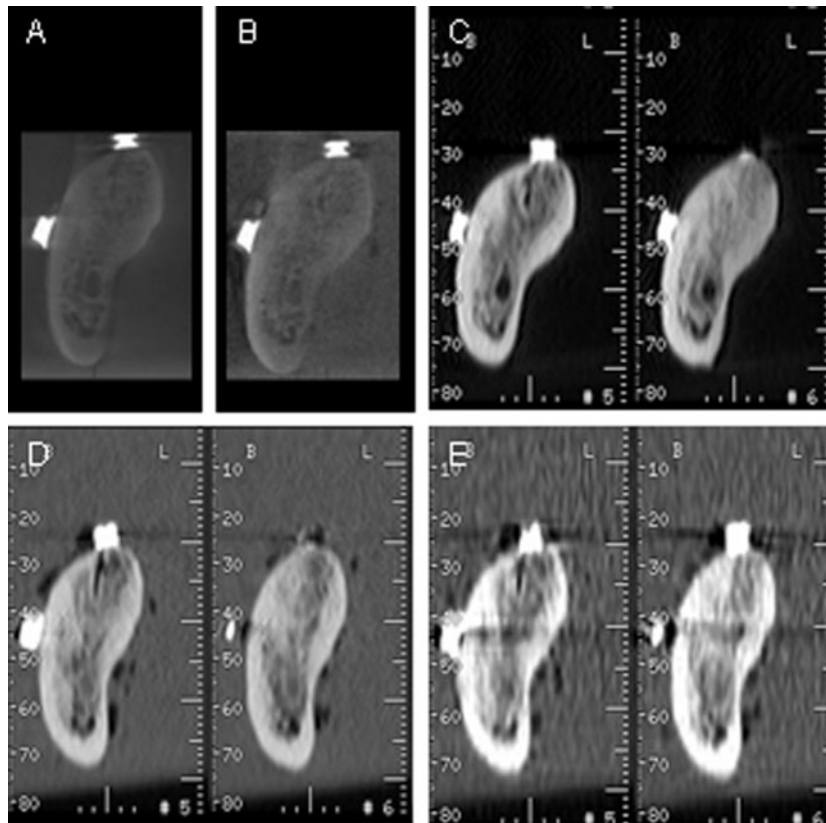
Cross-sectional images on the right side in the second molar region. A, cone beam CT (CBCT) image of dry mandible; B, CBCT image of mandible in sucrose solution; C, multislice CT (MSCT) images of dry mandible; D, MSCT images of mandible in sucrose solution using conventional scanning parameters SE 759; E, low-dose MSCT images of mandible in sucrose solution SE 905. For scanning parameters in MSCT, see Table 1. The images have been digitally enhanced
